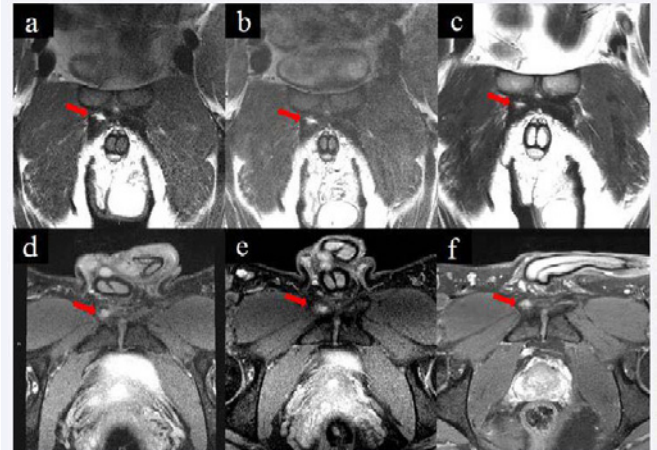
T2-weighted coronal MR-images (a, b, c) and corresponding axial and proton density fat saturated images (d, e, f) at the level of long adductor insertion gradus 2/3 partial tear: Immediately following trauma (arrows in the images a and d); conservative treatment at 4 months (arrows in the images b and e); after operative treatment at 1 year (c, f). The size of the lesion is practically unchanged it is just slightly more demarcated on later images (b, c, e, f).
